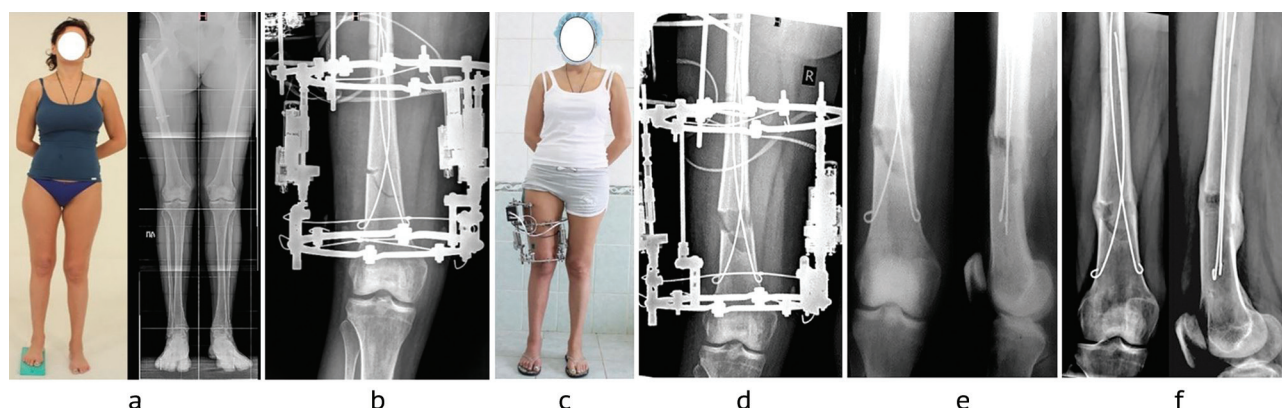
Patient, 42 years old, diagnosed with 2.5-cm post-traumatic shortening of the right thigh, foreign body in the right femur: a – photo of the patient and radiographs of the bones of the lower extremities before surgery; b – radiograph of the right femur on the day of surgery (corticotomy, combined osteosynthesis); c – patient in the course of treatment; d – radiograph of the right femur on the day of distraction completion; e – radiographs of the right femur after two weeks of fixation on the day dismantling the Ilizarov apparatus; f – radiographs of the right thigh three months after dismantling the apparatus
